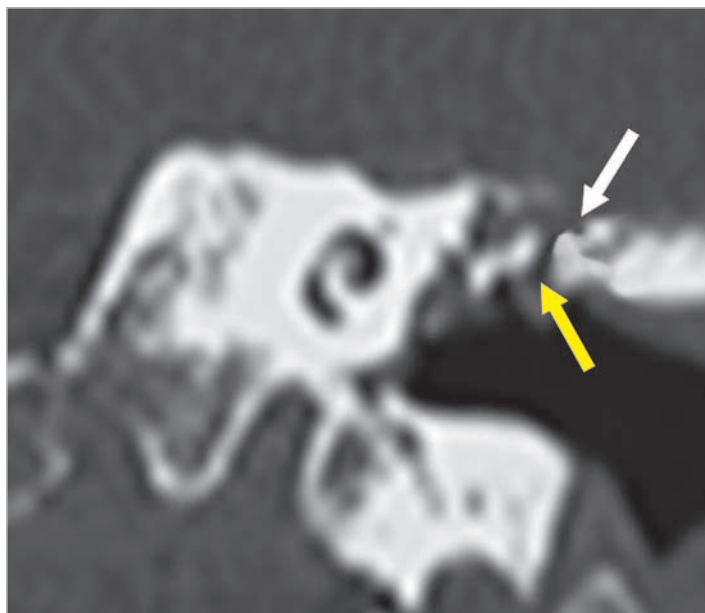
CT scan of the same case, coronal view. Epitympanic cholesteatoma with erosion of the head of the malleus (yellow arrow) and thinning of the tegmen tympani (white arrow).
